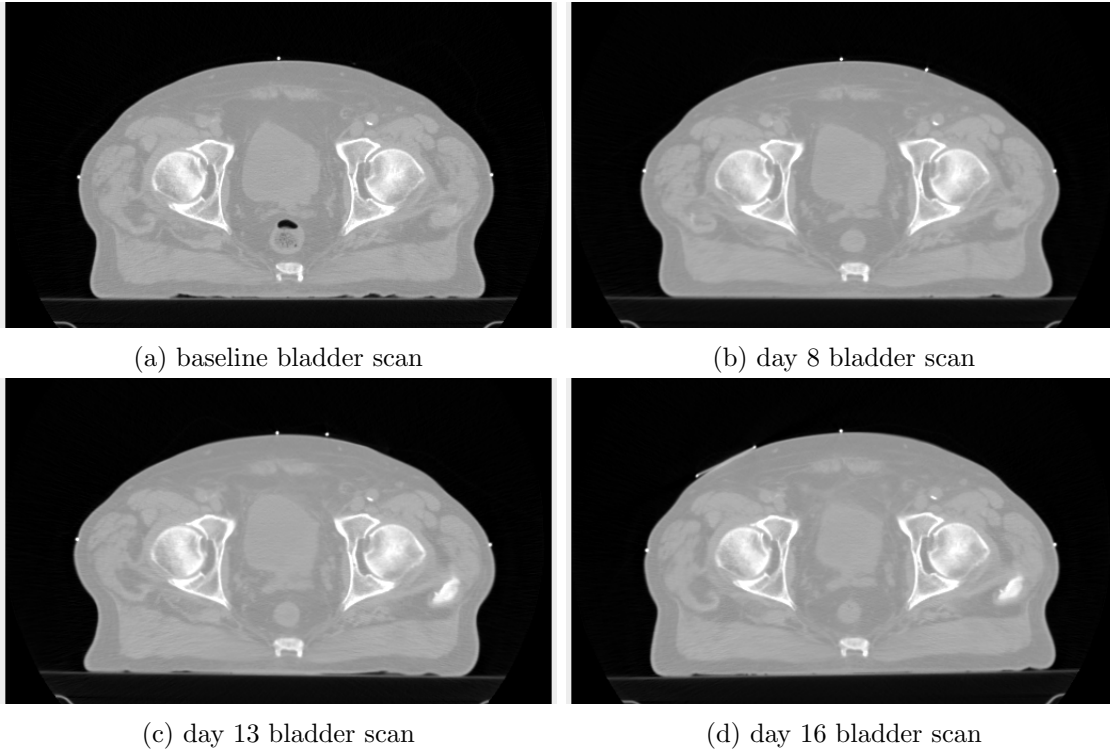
Four successive images from a series of CT scans of a bladder patient [6]. The three subsequent images are rigidly registered to the bones of the baseline scan.
